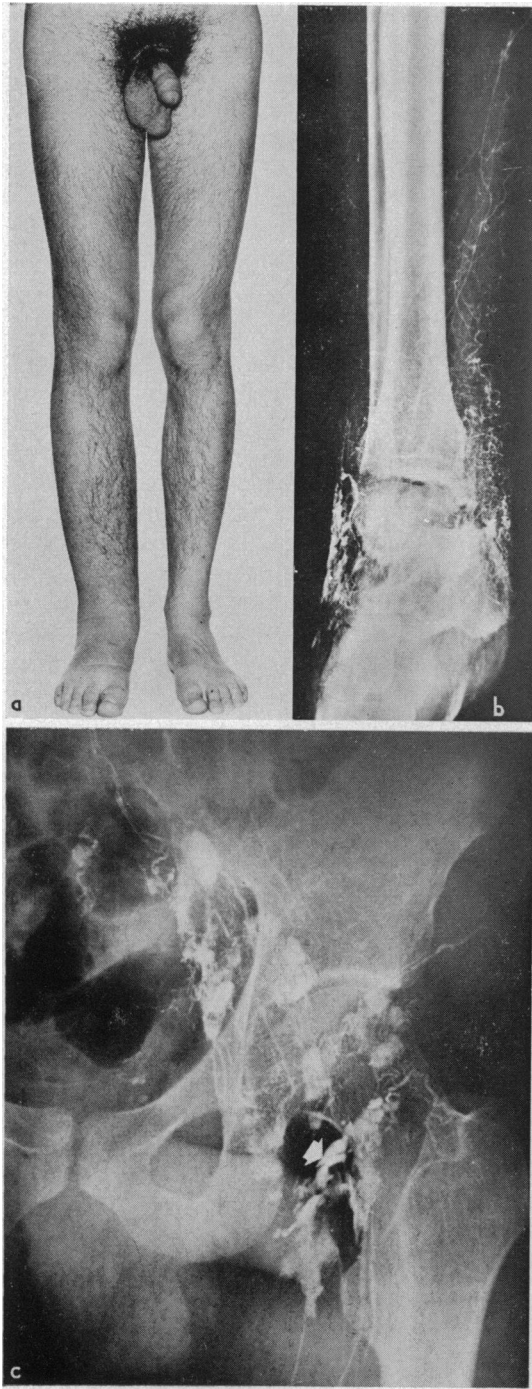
(a) Lymphoedema due to major hypoplastic changes originating in the nodes in the trunk in man aged 24. Swelling of right leg and thigh of spontaneous origin for 2 years and right hydrocele of 10 years' duration. Left leg remains clinically normal despite nodal changes in lymphograms. (b) Obstructive appearance shown after injection in lymphatic on right foot. Retrograde flow into tortuous lymphatics reaching dermal plexus of foot and ankle. A single small irregular lymphatic runs upwards to knee. (c) Early node-filling phase of lymphogram on patient's left (good) side. There are 4 afferents in the groin (normal 5 or more). Nodes are irregular and extravasation is starting (arrow). The efferent vessels are small and tortuous. Also collateral formation and retrograde flow both medially and laterally (cf Fig. 2). There is as yet little obliteration of vessels on this side. (Despite the X-ray changes the patient has remained free of oedema on this side, presumably through adequacy of the collateral circulation.) (d) Lymphadenograms (24-h films) show almost no nodes outlined on the right. There is a single node in line with the femoral head and an ectopic node near the iliac crest. On the left side there is extensive disease of nodes (cf Fig. 2). Many are smaller and denser than normal and lie out of the normal position. Inguinal nodes are numerous, small, and round. There are areas of extravasation of dye, not normally seen (arrow).
